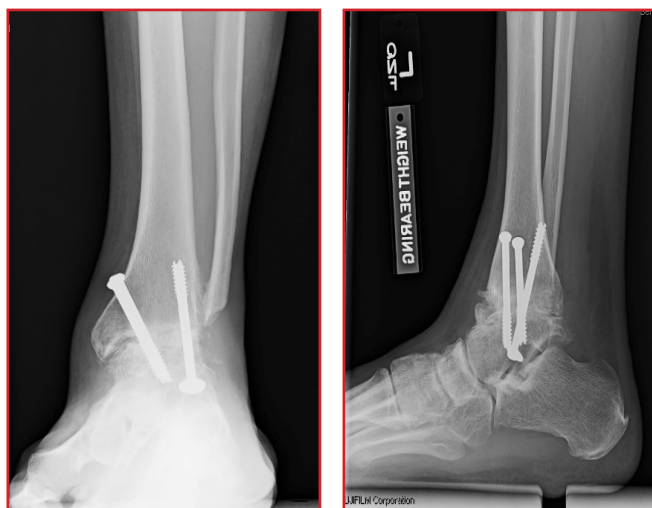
Postoperative radiographs of the left ankle joint obtained immediately after ankle fusion, showing initial improvement of joint space.
